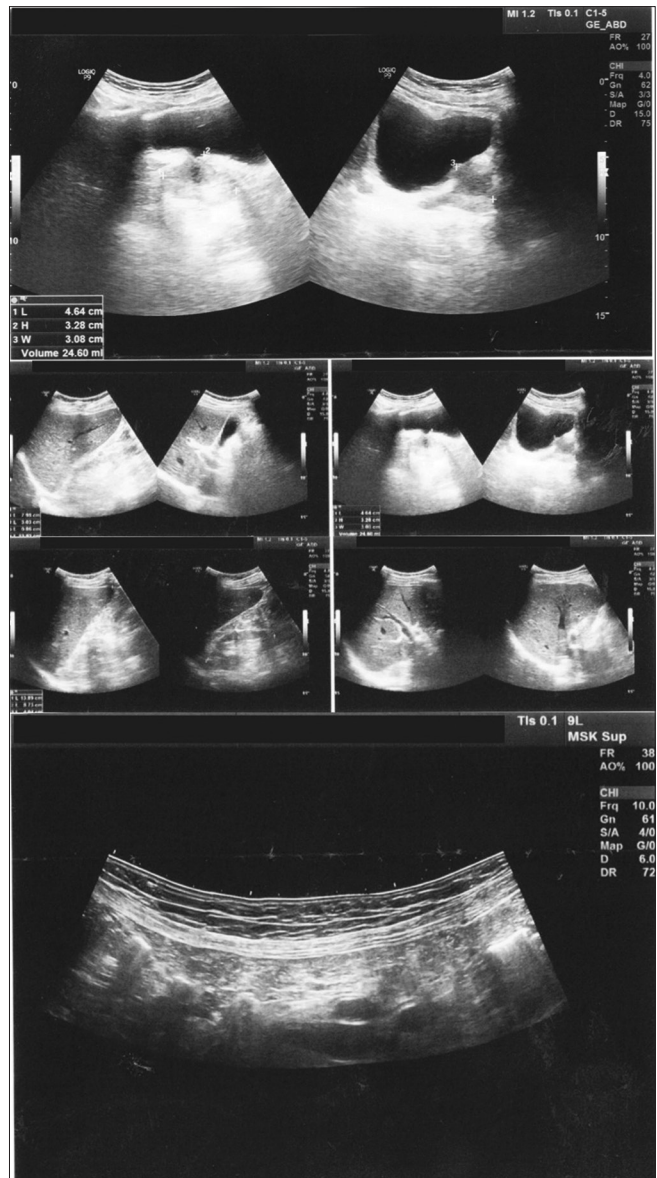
Ultrasonography showing normal appendix after treatment
